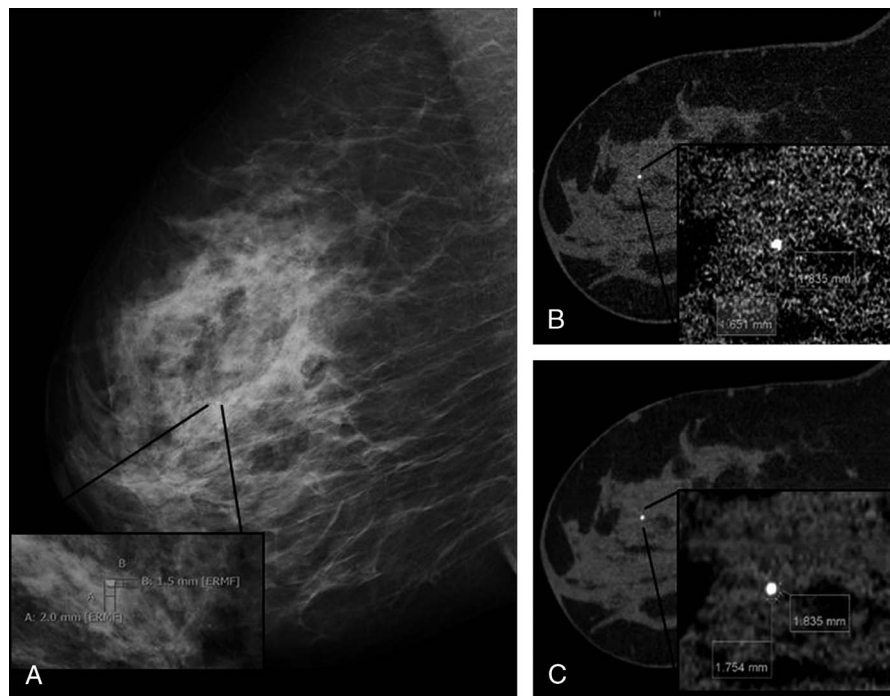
A 57-year-old woman with known microcalcification and macrocalcification of the breast. A macrocalcification is visible in the mediolateral oblique mammogram in the central retroareolar region and magnification is provided (A). Mammography was performed 24 months before B-CT. HR (B) and ST (C) and corresponding magnification of the macrocalcification are provided. Although the 2 examinations were performed in a long time interval and variation of calcification size cannot be excluded, similar values of maximal diameter were measured. Concerning B-CT images, almost identical values could be measured in the images obtained with both HR and ST.
